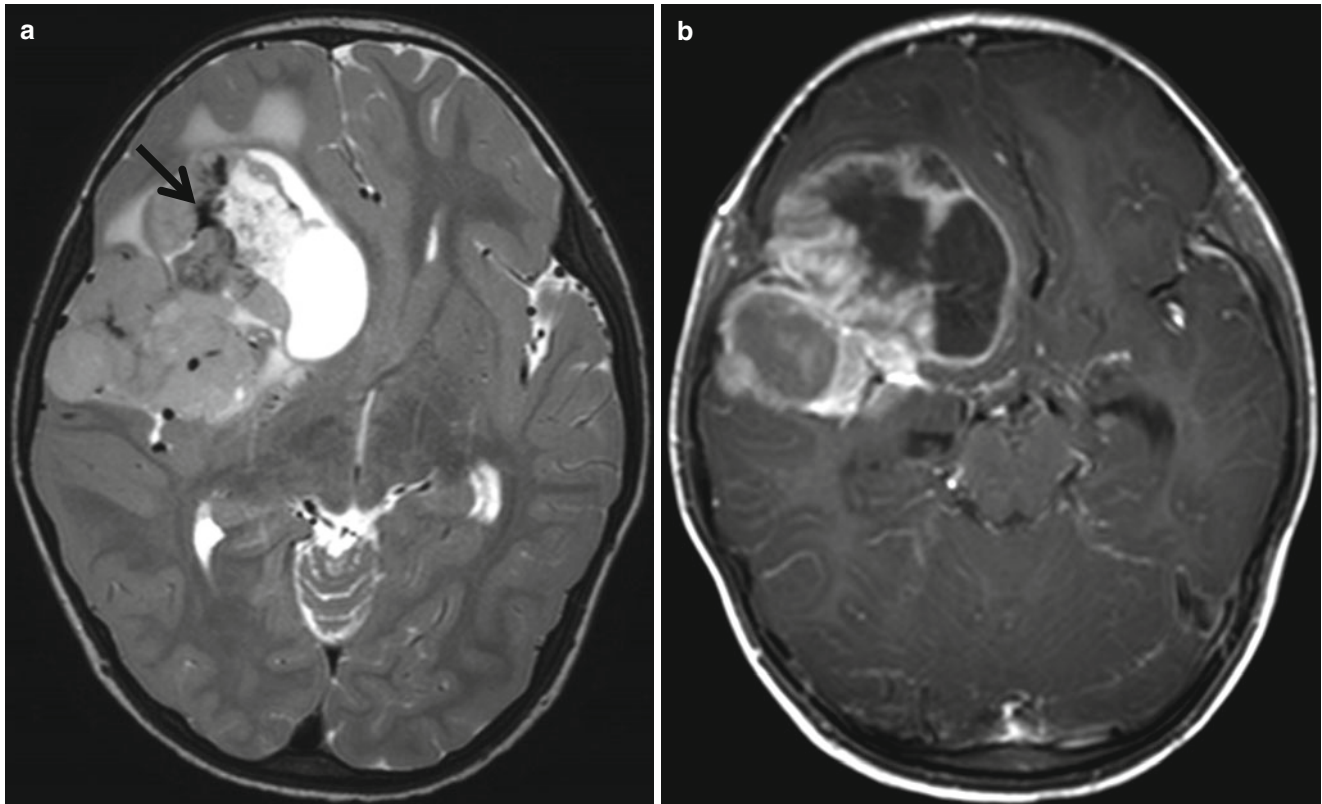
Supratentorial ependymoma in a 3-year-old boy. (a) T2-weighted image shows solid and cystic mass in the right fronto-temporal lobe. The mass contains dark intensity (*arrow*), suggesting
